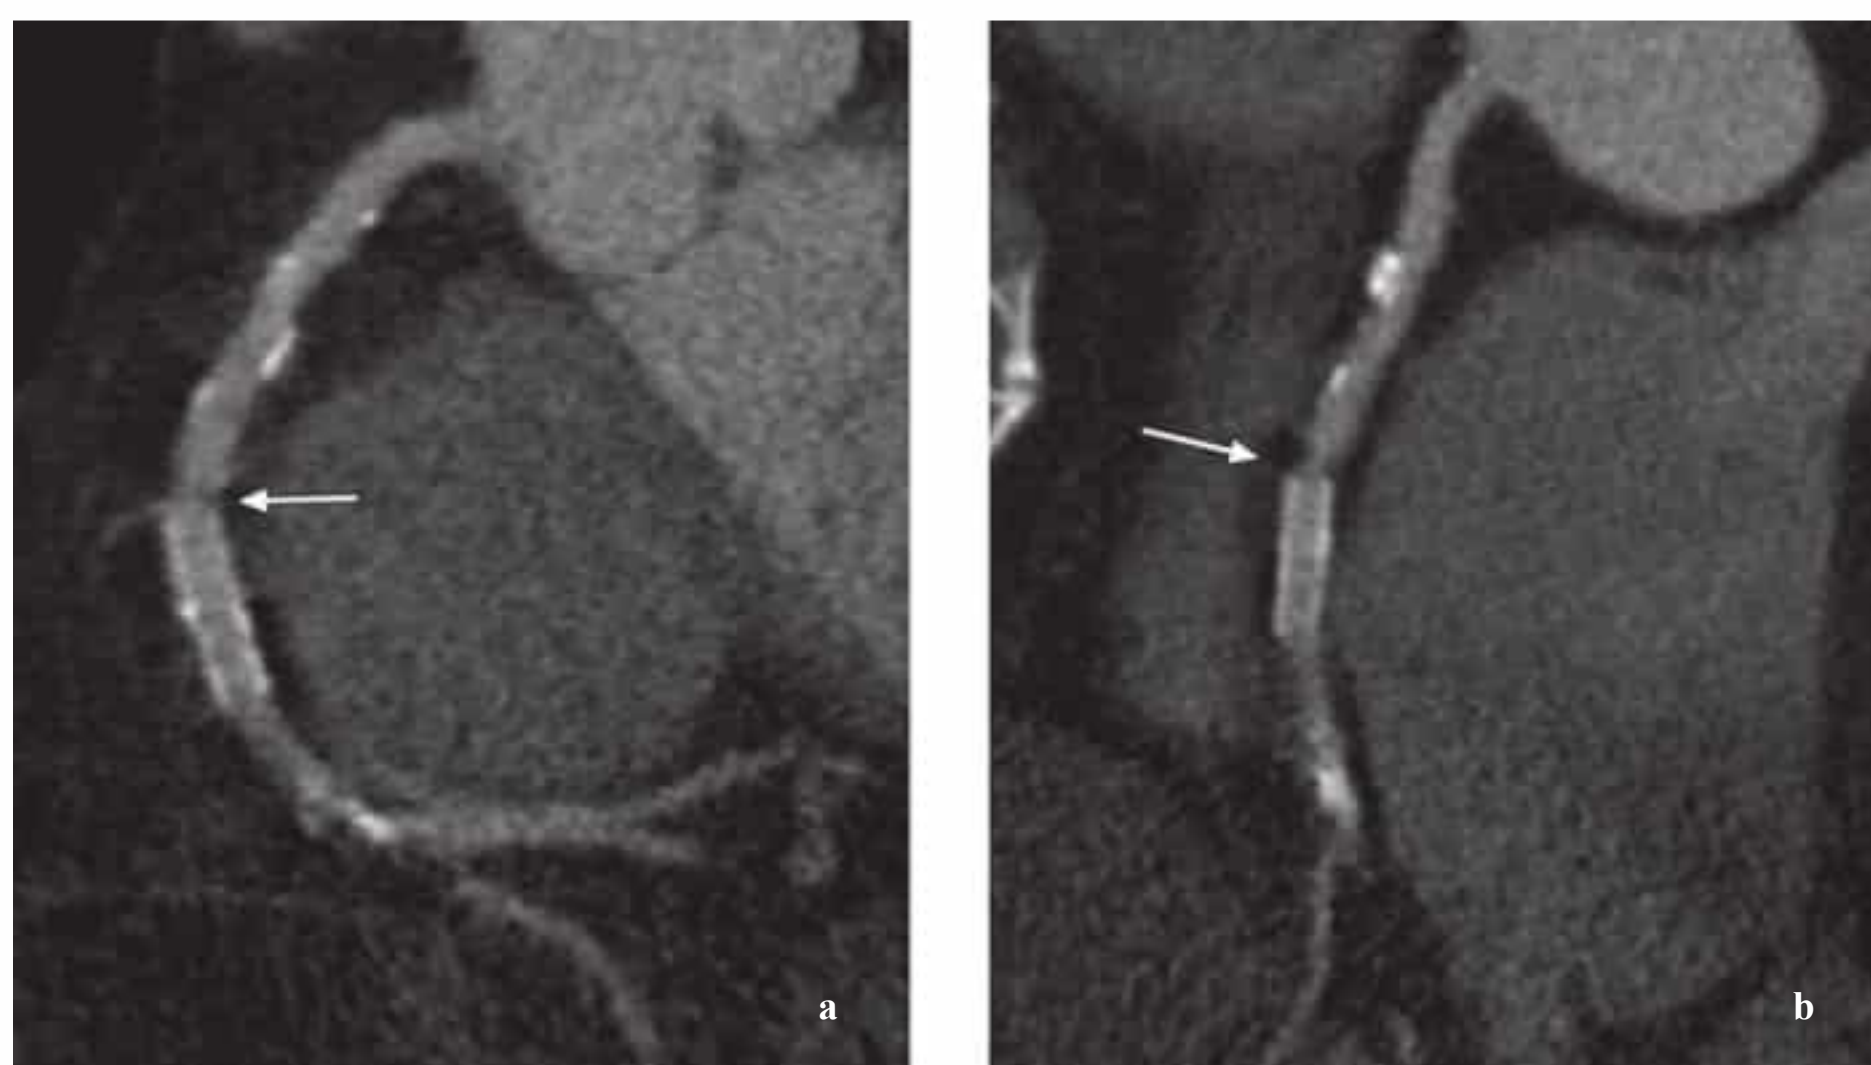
a, b A 59-year-old man after stent placement in the RCA. MPR images of cardiac CTA show a stenosis proximal to the stent (arrow).
